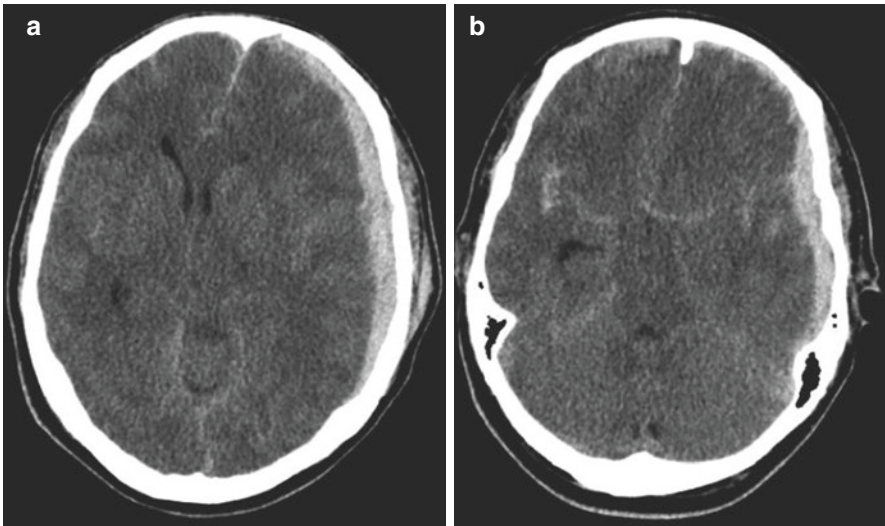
(a, b) CT head reveals a left extra-axial hyperdense collection, associated with effacement of the local sulcal-gyral pattern, uncal herniation, effacement of the basal cisterns, and midline shift to the right that is disproportionate to the maximum thickness of the subdural hematoma. This constellation of radiographic signs, coupled with evidence of primary parenchymal injury such as contusion or edema, suggests the need for a decompressive hemicraniectomy (i.e., leaving the bone flap out) at the time of surgery
